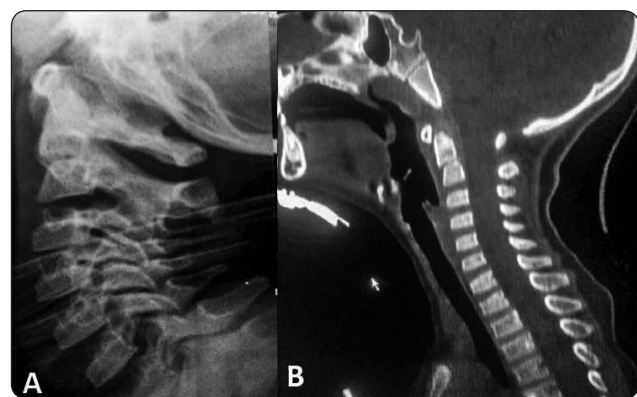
(A,B) Plain radiograph and sagittal CT scan immediately after application of the Minerva showing realignment of the dens.
